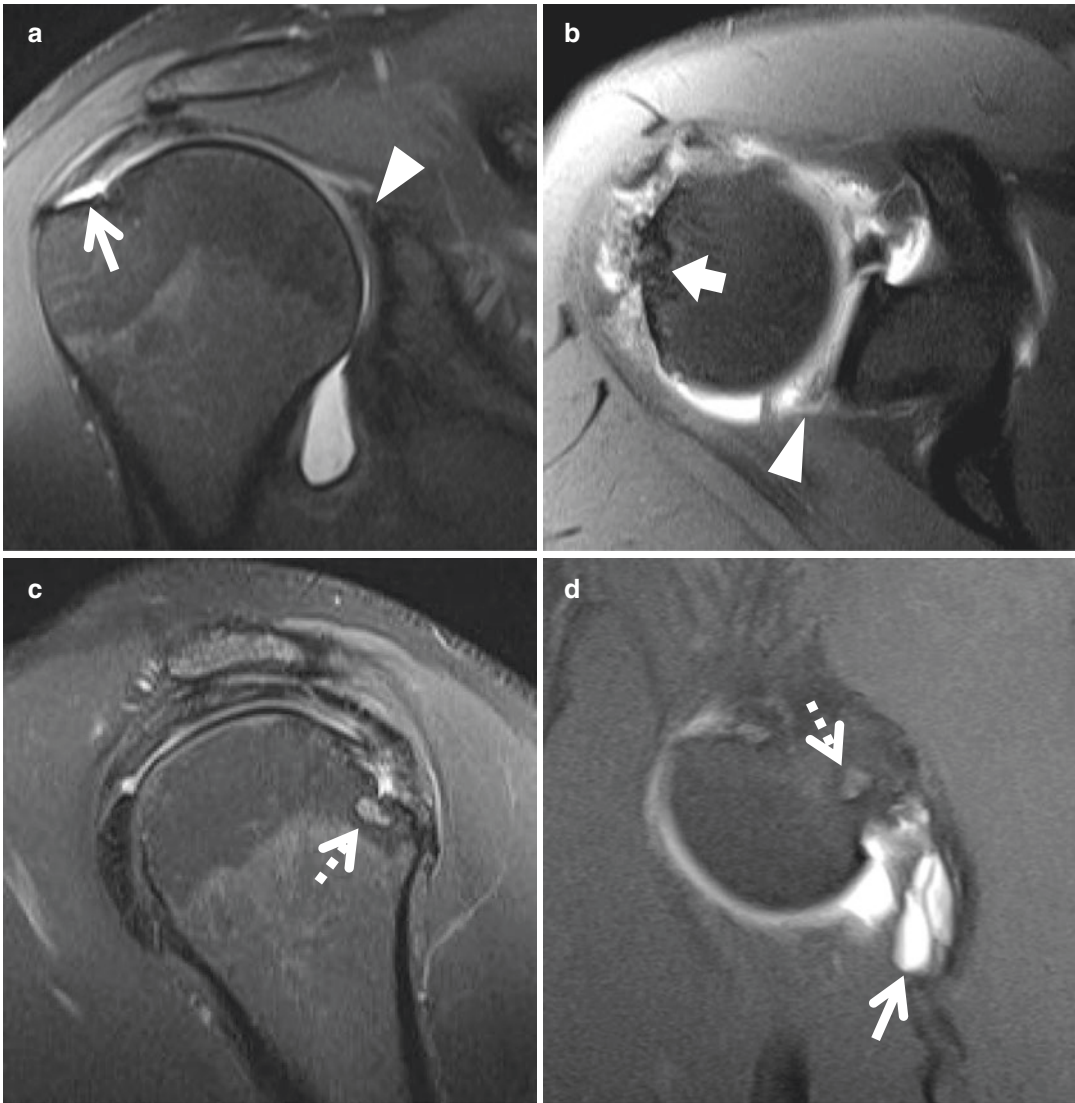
MR arthrogram images of a 30-year-old major league baseball pitcher with shoulder pain. (a) Coronal intermediate-weighted fat-suppressed image shows a high-grade, partial-thickness, articular sided tear at the footprint of the supraspinatus-infraspinatus tendon junction (arrow). A posterosuperior labral tear is present (arrowhead). (b) Axial T1-weighted fat-suppressed image confirms labral tear (arrowhead) and shows
